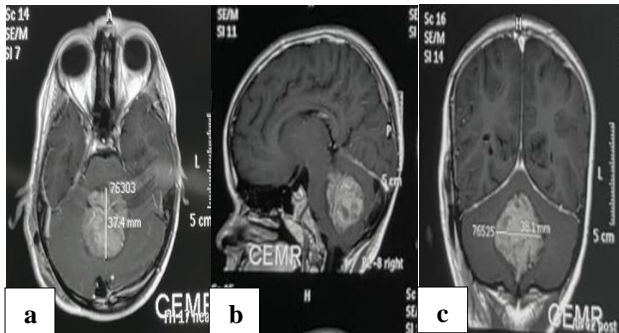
(a-c): Heterogeneous low signal intensity on T1-weighted images, and exhibited nonhomogeneous central bright signal areas on T2-weighted images, accompanied by fairly heterogeneous enhancement following contrast administration.
